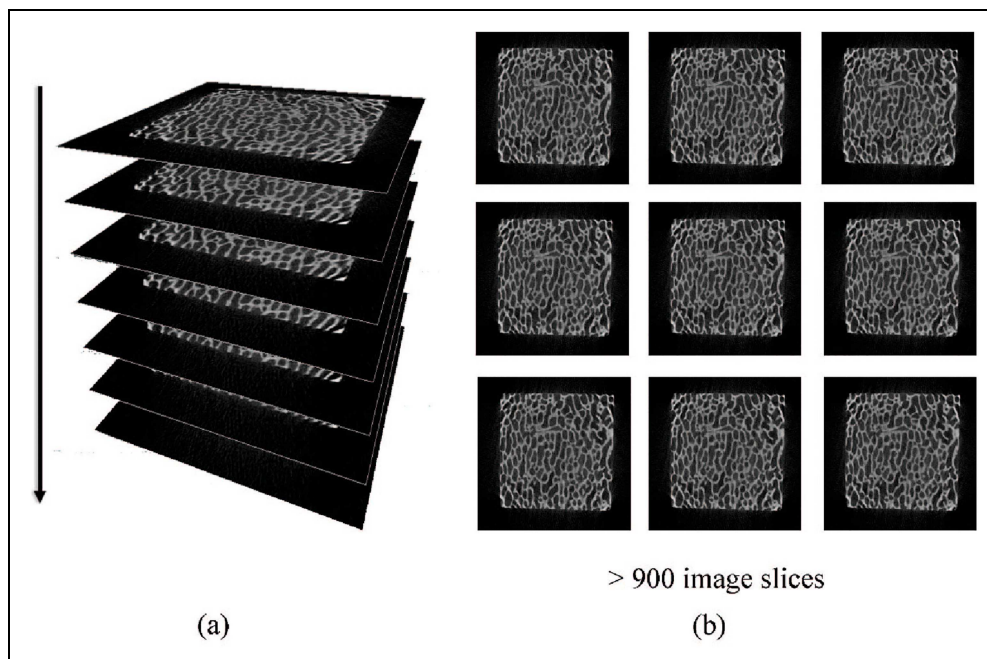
Images obtain from μ -CT scan with (a) images stacked in sequence according to sample orientation (b) raw scanned images file.
